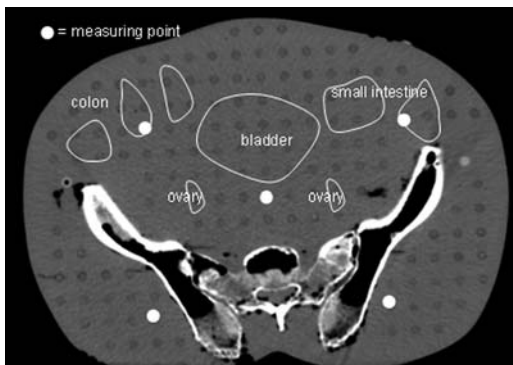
CT tomogram with organs and measuring points drawn in.
